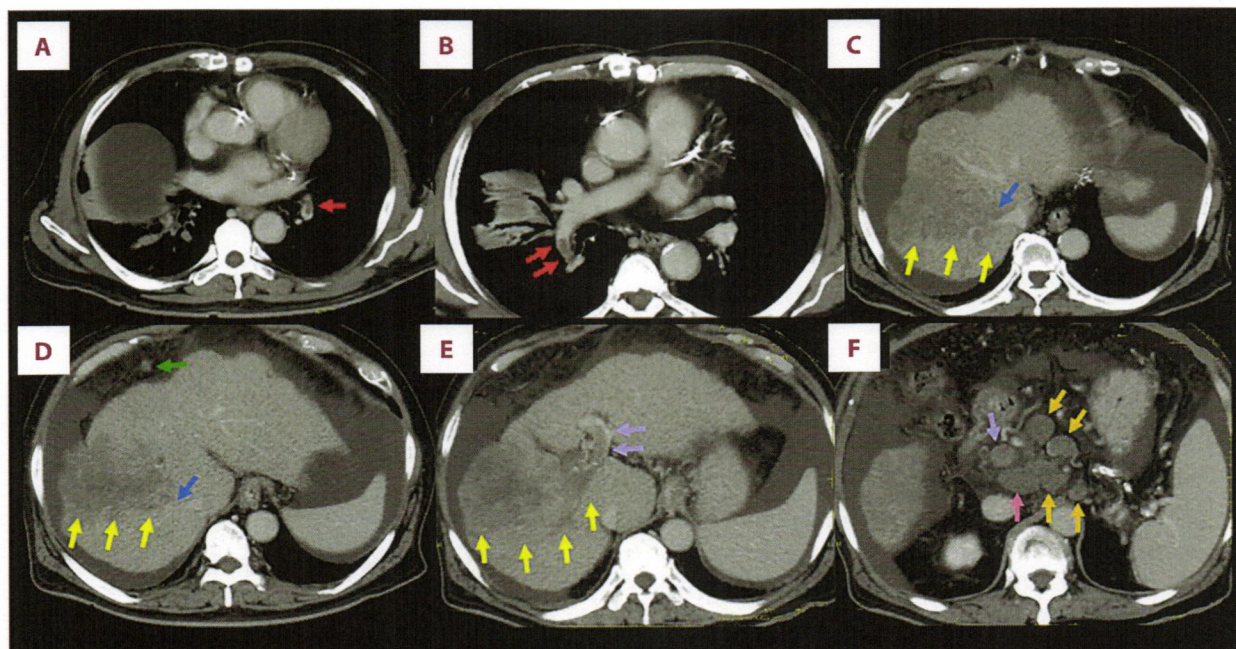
Enhanced CT findings 67 days after the initial diagnosis. New pulmonary arterial thromboses were observed (A, B, red arrows). The primary hepatic tumor had further enlarged (C-E, yellow arrows), along with metastatic lymph nodes (F, pink and orange arrows). Tumor thromboses had extended into the right and middle HVs (C, D, blue arrows), while PV thrombosis progressed into the left PV and PV trunk (E, F, blue arrows). Additionally, massive ascites (C-F) and new intraperitoneal dissemination (D, green arrow) were detected. CT – computed tomography; HV – hepatic vein; PV – portal vein.
